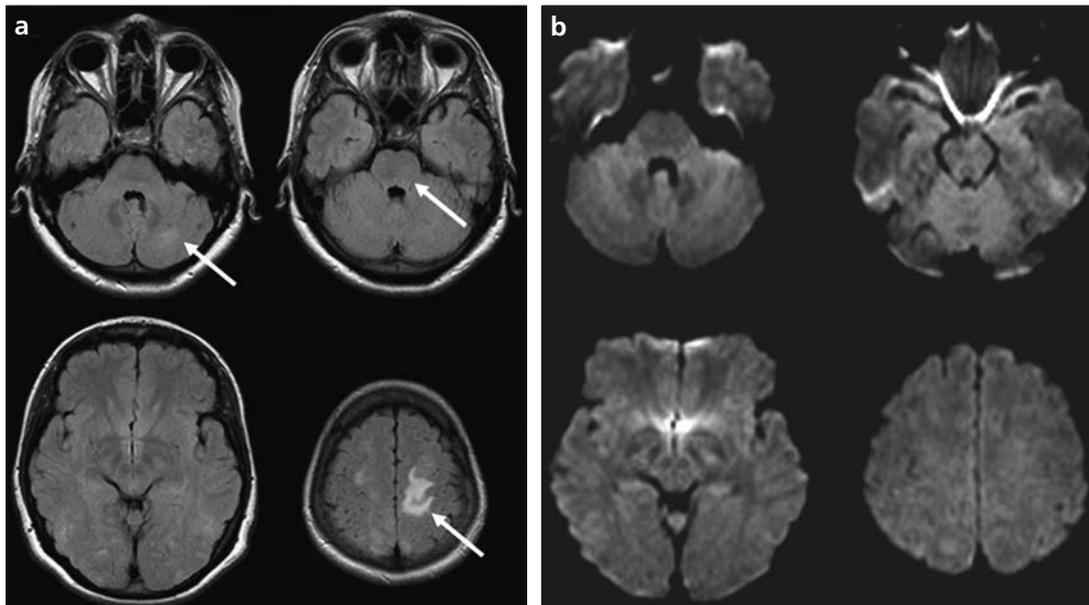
a, b. Two days after the initial MRI, repeat MRI demonstrates considerable regression of the multiple supra- and infratentorial hyperintense signal abnormalities on transverse FLAIR images (a) (arrows) and diffusion-weighted MRI (b). Apparent diffusion coefficient map was normalized.
